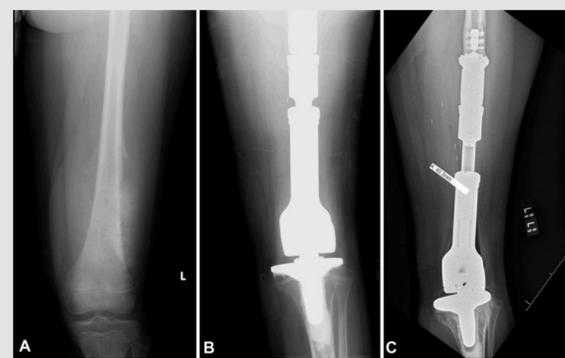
X-ray images of a 11-year-old male patient whose distal femur was reconstructed using an expandable endoprosthesis after osteosarcoma removal. Image A: preoperative view of the femur; Image B: immediate postoperative view; Image C: 2-year postoperative view. An expandable endoprosthesis is a special type of endoprosthesis that replaces a missing body part inside of the body with a device that can automatically expand. The various expansion mechanisms inside the device allow it to elongate without additional surgeries making the procedure perfect for growing children.
